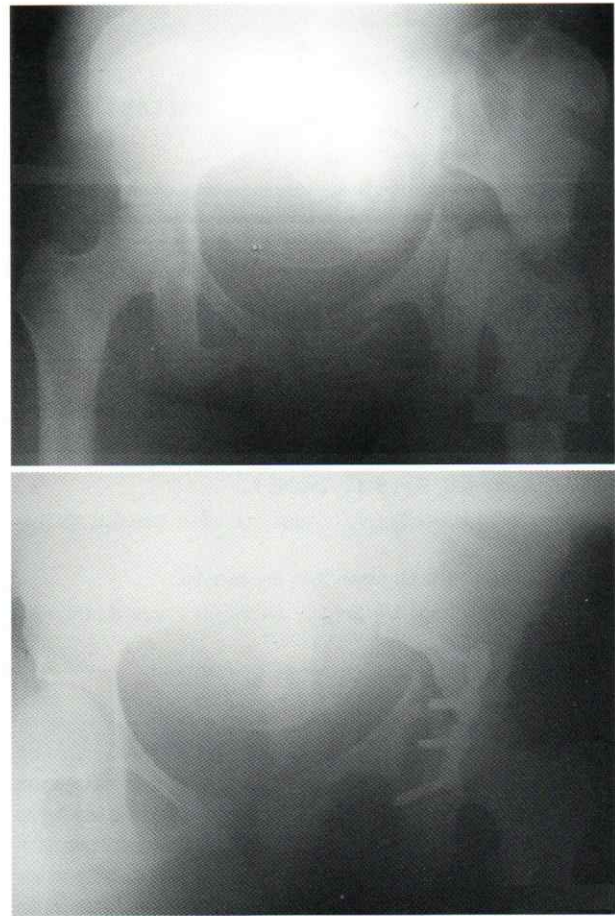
Patient 1: Radiographs showing a T shape fracture of the acetabulum with femoral head protrusion, foetus in cephalic presentation (a): X-ray before surgery (b): X-ray after surgery
